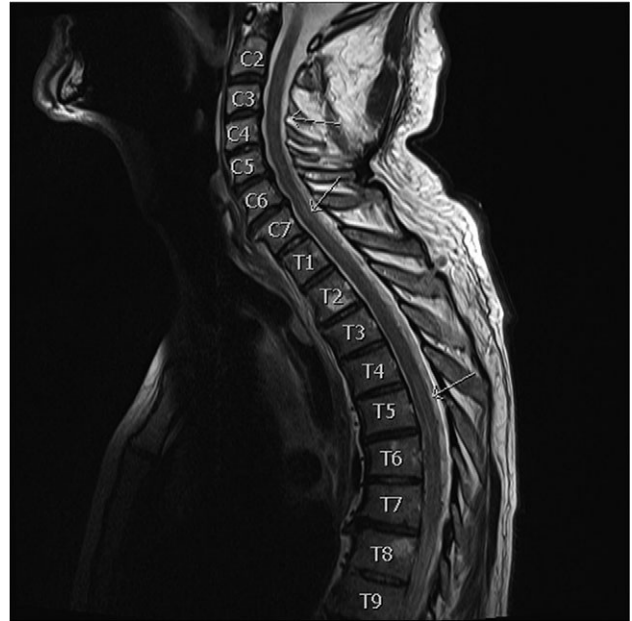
MRI spine T2 sagittal pre contrast. Arrow indicates areas of extensive spinal leptomenigeal involvement.
